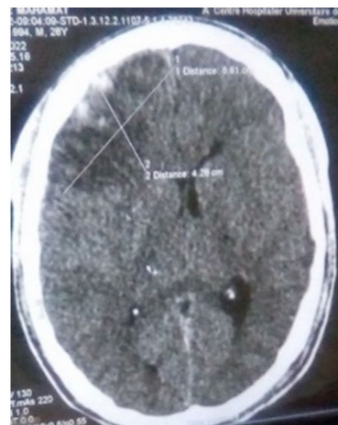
An axial section of the brain CT, showing spontaneous hyperdensity in a left Temporo-Parietal biconvex lens, indicating an extra-dural hematoma.
